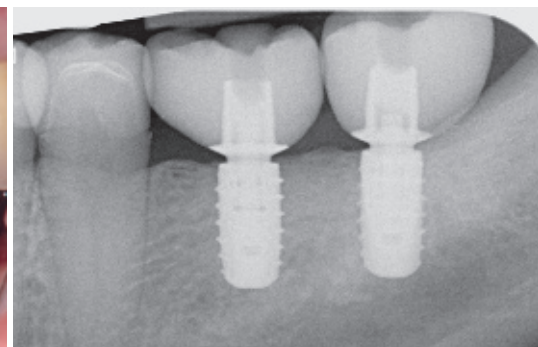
An impressive result seen in the radiograph 25 months after surgery.
